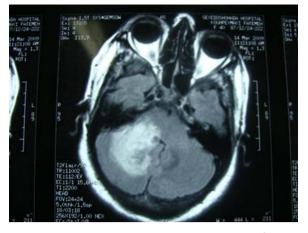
MRI without contrast showed a partially well-defined and irregular mass-like lesion in the right brachium pontis without significant mass effect.
